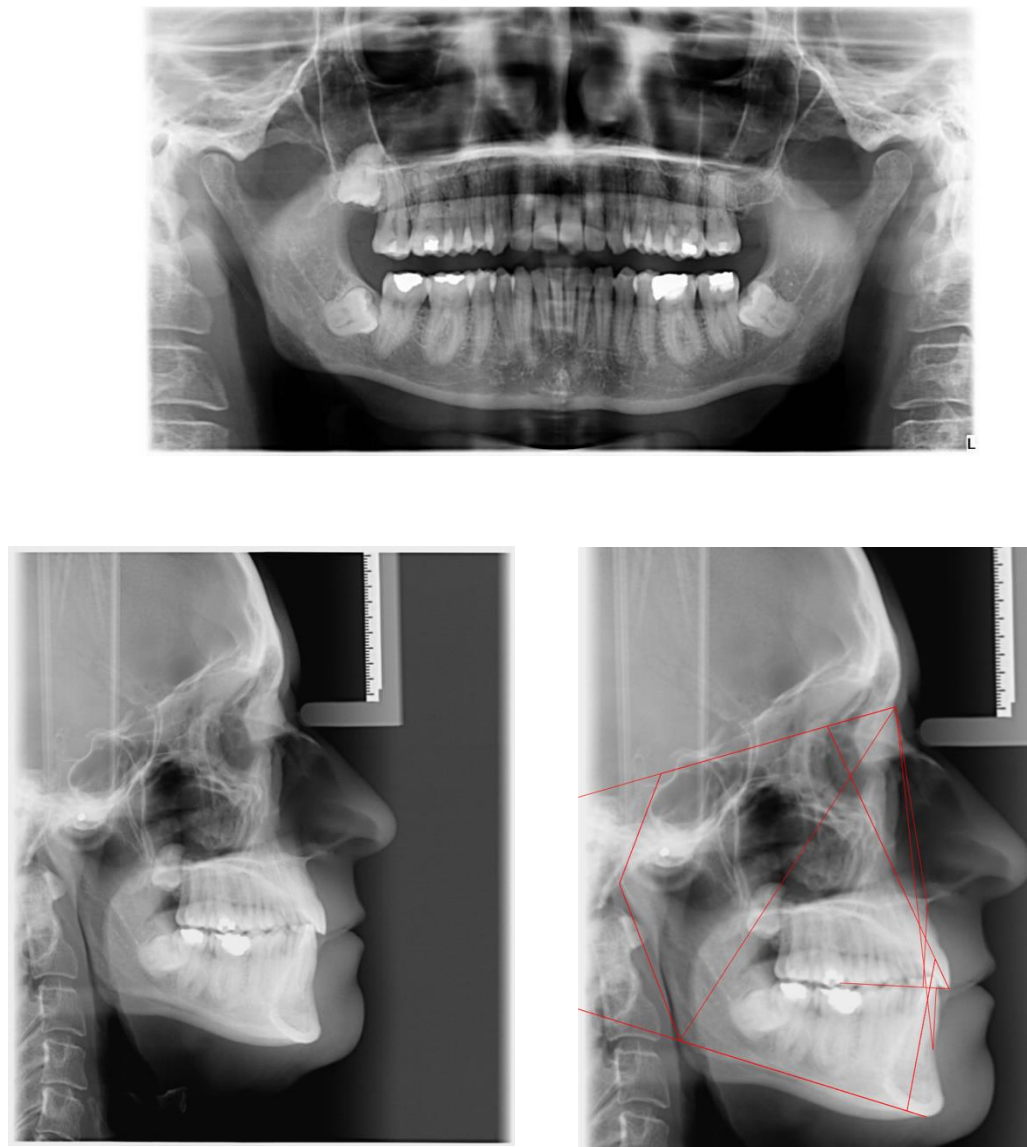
Post-treatment radiograph and cephalometric analysis.*
